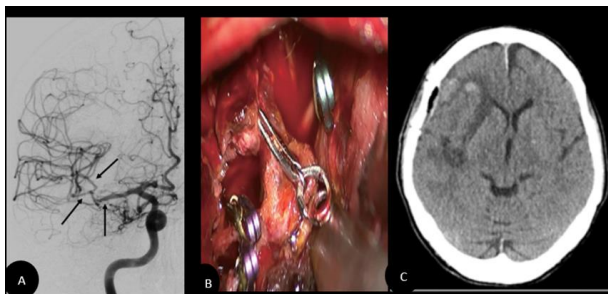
a) Intraoperative clip of the aneurysm with recurrence, b) postoperative with images of the M1-M2 and MCA segments, with active vasospasm, c) Post operative computed tomography example after treated the patient.
